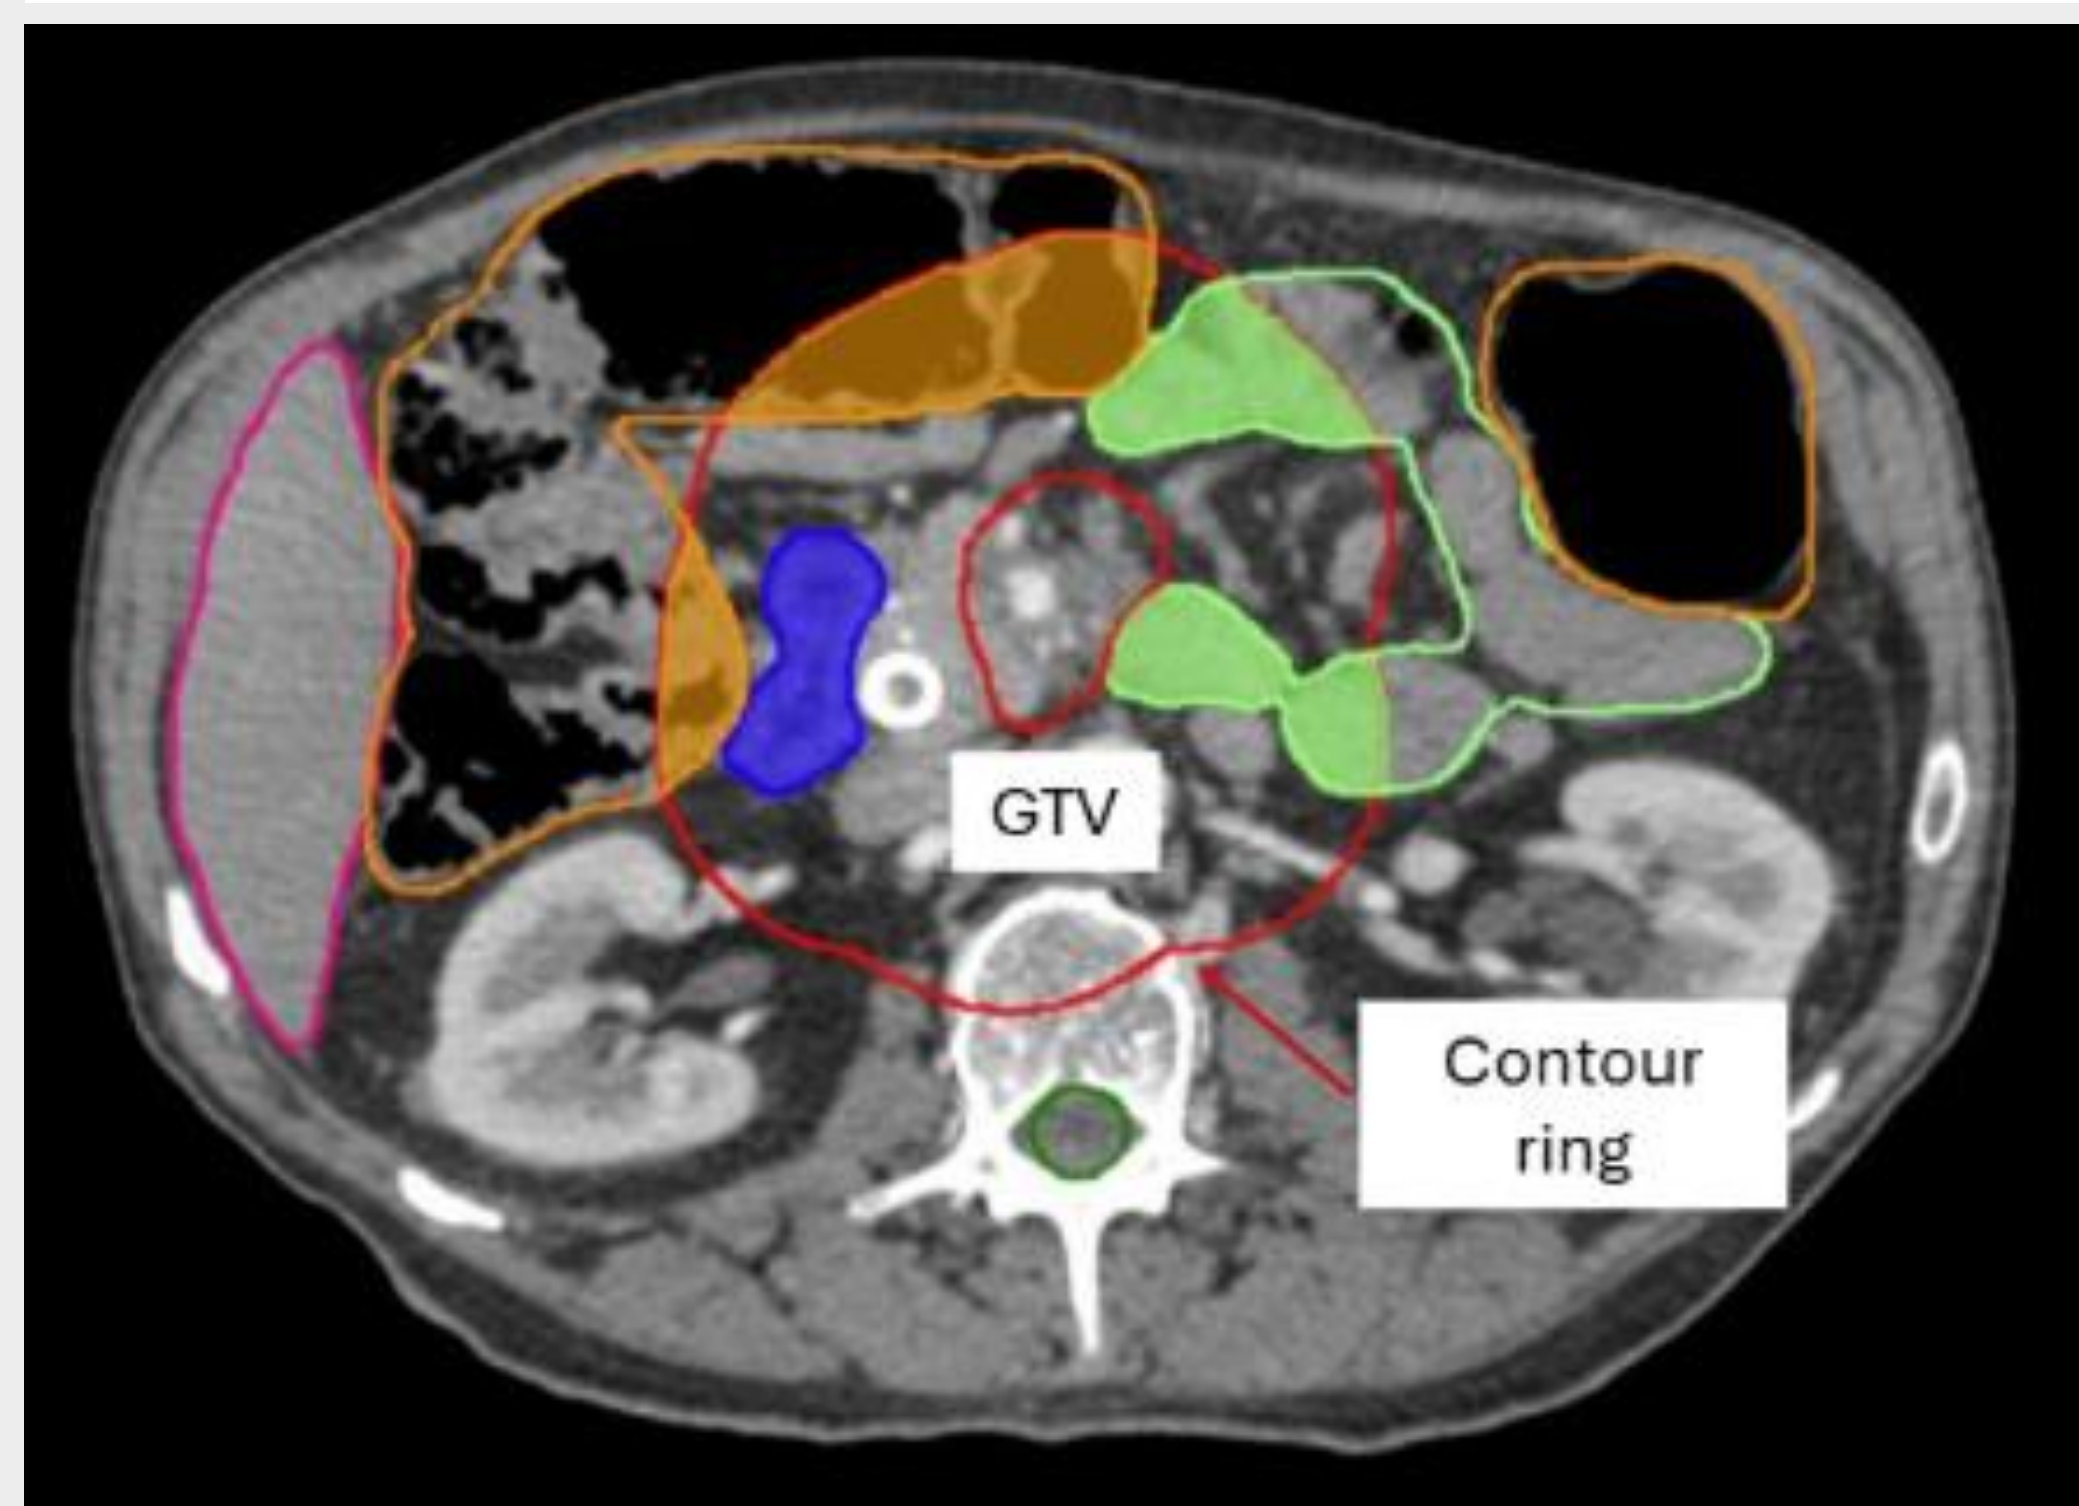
Axial CT slice showing the target and OARs: duodenum (blue), stomach (yellow), large bowel (orange), and small bowel (green). A contour ring (red) was generated from a PTV expansion, to define a proximity region. Only OAR subvolumes intersecting it were used for cropped plan optimization, whereas the original clinical adaptive plan used the full OAR volumes.
